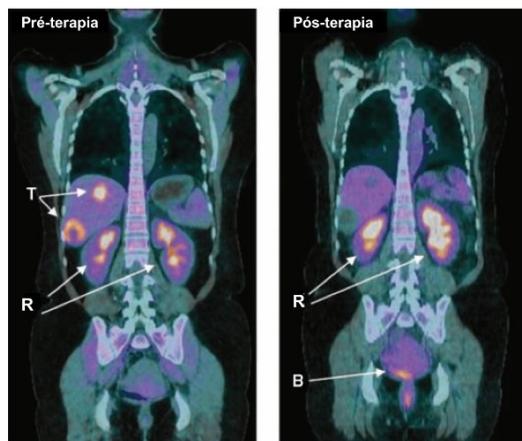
Captação de glicose por tumores (T), visualizada por PET com FDG em resposta à terapia. O tumor (T) é facilmente identificado antes da terapia (esquerda) e não observado após terapia (direita). O excesso de FDG é excretado pela urina e, portanto, é possível visualizar também os rins (R) e a bexiga (B) (VANDER HEIDEN; CANTLEY; THOMPSON, 2009).
